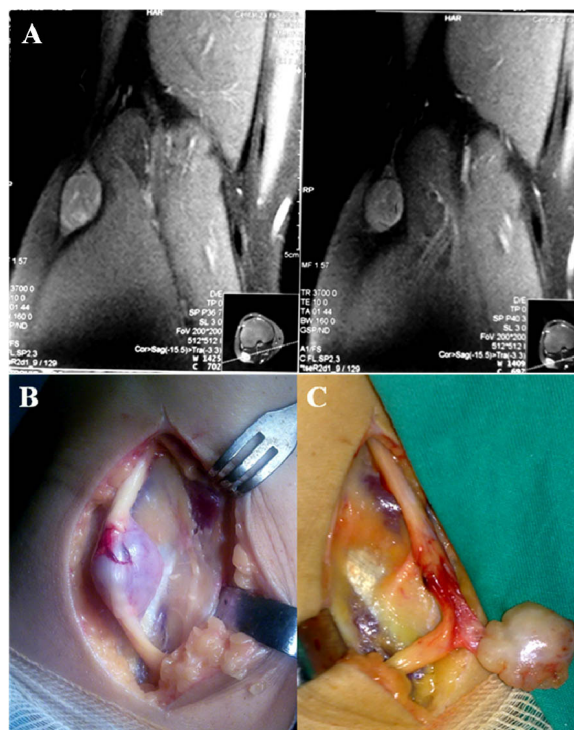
A) Sagittal images of magnetic resonance imaging of the left knee of 41-year-old man presenting with intermittent left knee pain, showing a well-defined tumor mass of the posterolateral aspect of the knee; B) Surgical exposure of the common peroneal nerve schwannoma via a lateral surgical approach excision; C) Tumor excision *in toto* after careful dissection of the perineurium with preservation of the macroscopic nerve integrity.
